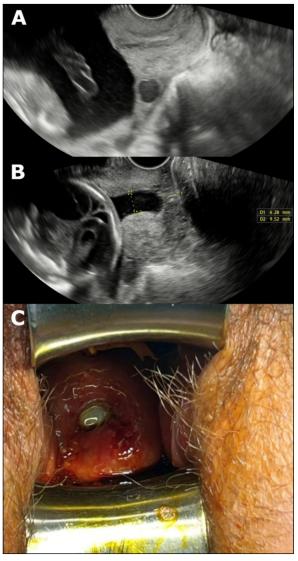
A representative case with visible types of prolapsed fetal membranes A, An ultrasound image of the cervical canal mimicking normal cervical length during pressure with a vaginal probe. B, An ultrasound image of the same cervical canal after releasing the pressure of the vaginal probe, indicating the importance of the technique of the placement of vaginal probe for an accurate diagnosis of cervical insufficiency. C, A vaginal image of visible type of prolapsed fetal membranes from the same case as mentioned above.
